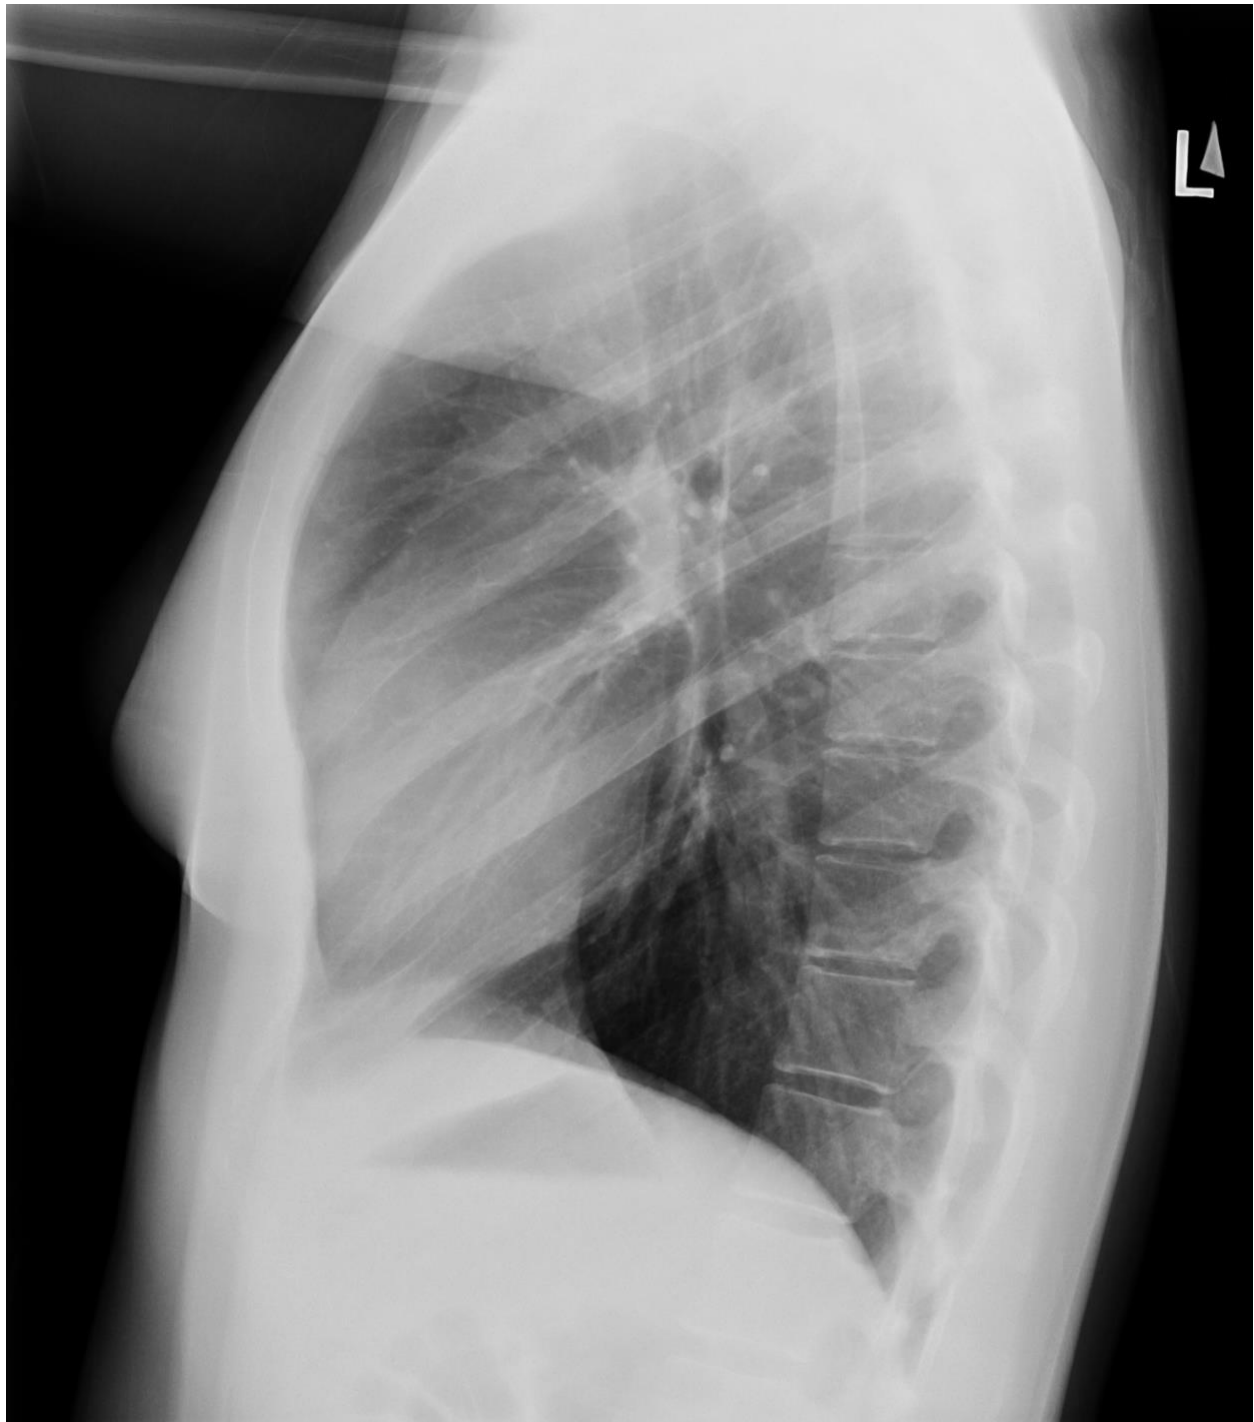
Lateral Chest X-ray with normal vertebral bodies for comparison.
